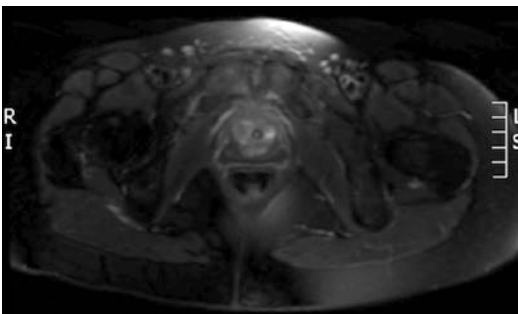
T1 axial MR image of enhancing circumferential periurethral mass suggestive of malignancy
